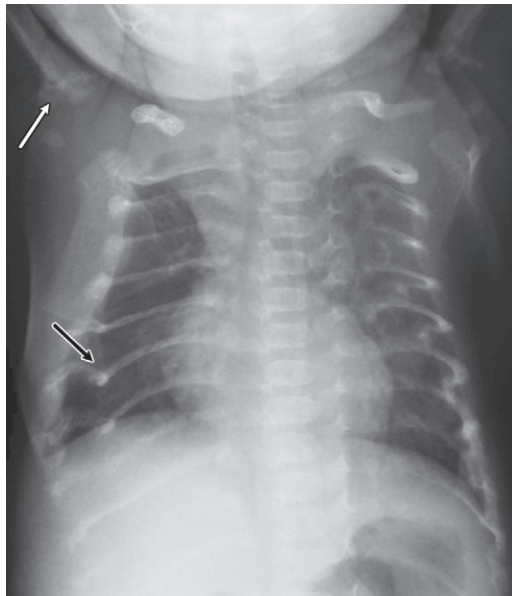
Diffusely thin ribs with fractures in a neonate with hyperparathyroidism. Frontal chest radiograph shows diffusely thin ribs with multiple fractures (black arrow) and deformities as well as subperiosteal resorption of the proximal humeri (white arrow).
